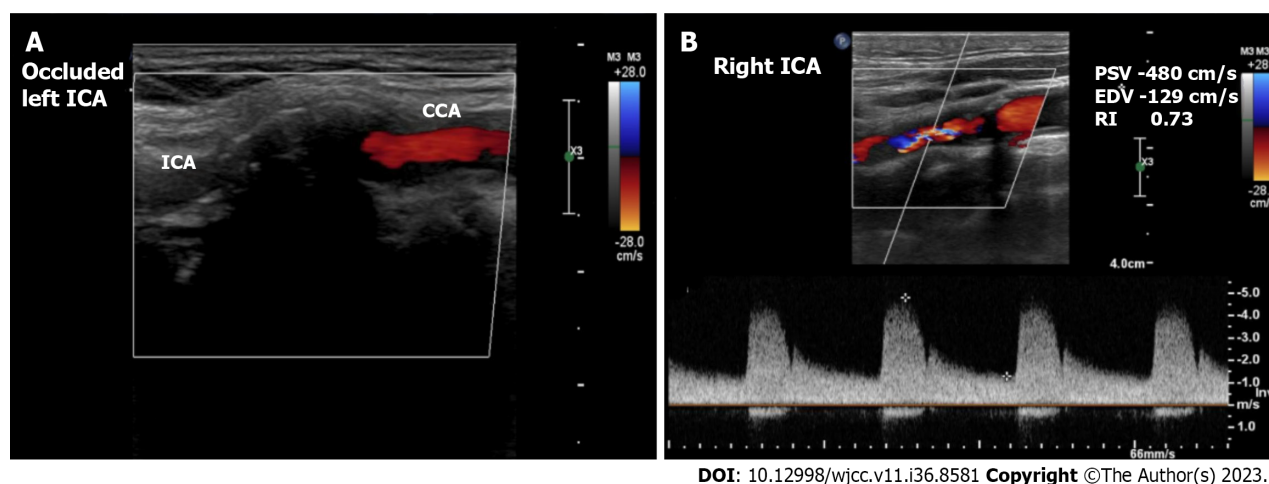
Preoperative carotid ultrasound duplex in case 2. A: Totally occluded left internal carotid artery; B: Right interval carotid artery stenosis of > 90%. CCA: Common carotid artery; EDV: End-diastolic velocity; PSV: Peak systolic velocity; RI: Resistance index; ICA: Internal carotid artery.
